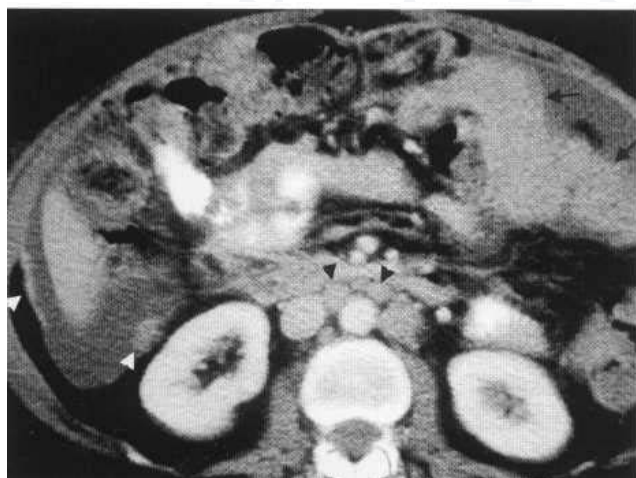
CT. Patient with ovarian carcinoma, peritoneal deposits (white arrowheads), para-aortic lymphadenopathy (black arrowheads) and 'omental cake' (black arrows).
